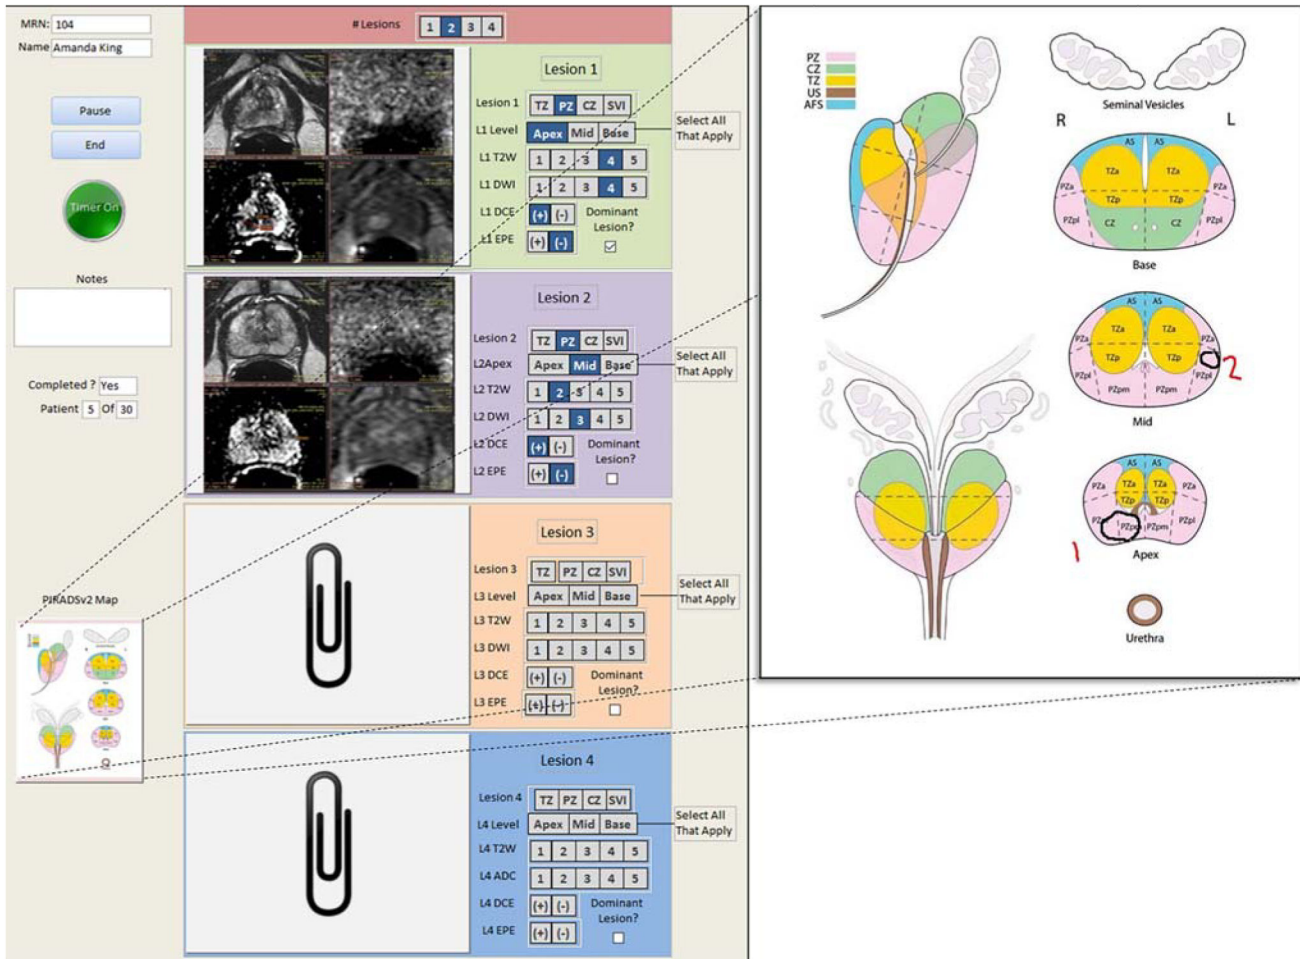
Application to collect PI-RADS reports. Shown is a screen shot of the application coded in Microsoft Access used in this study. Readers were shown the fictional-MRN and name indicated to open a study. After detecting all lesion/s on a given prostate mpMRI study, readers uploaded screen shots of each lesion clearly demarcating the long axis on the dominant sequence. They then indicated the zone (TZ, PZ), level (apex, mid, base), and PI-RADS score for T₂W, DWI, and DCE imaging. After saving screen shots, readers opened the PI-RADS map and drew the borders of each lesion on the PI-RADS sector map.
